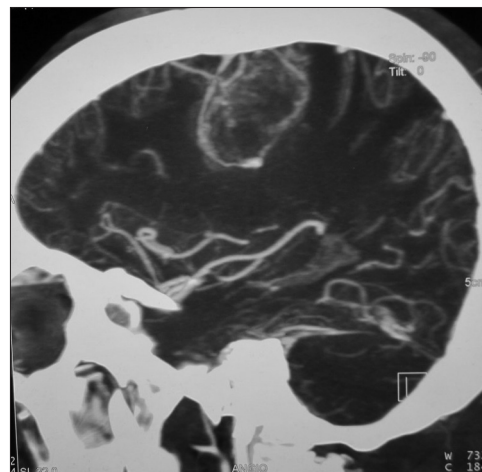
CT angiography showing a small lesion in the left high parietal region with increased vascularity
